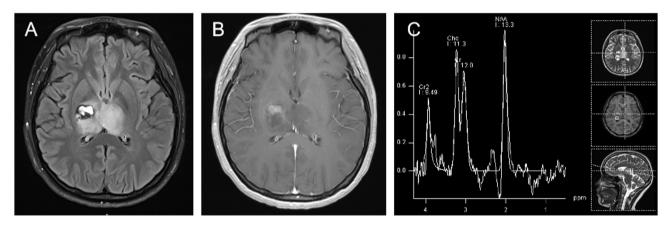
Head magnetic resonance imaging (1 month postoperatively, November 2021). (A and B) Partial resection of the right-hand side lesion, with residual thalamic glioma on the left side. (C) A markedly elevated peak in choline, a slight decrease in creatine and an N-acetyl aspartate/creatine ratio of <1.5 indicating a residual tumor. Cho, choline; Cr, creatine; NAA, N-acetyl aspartate.
